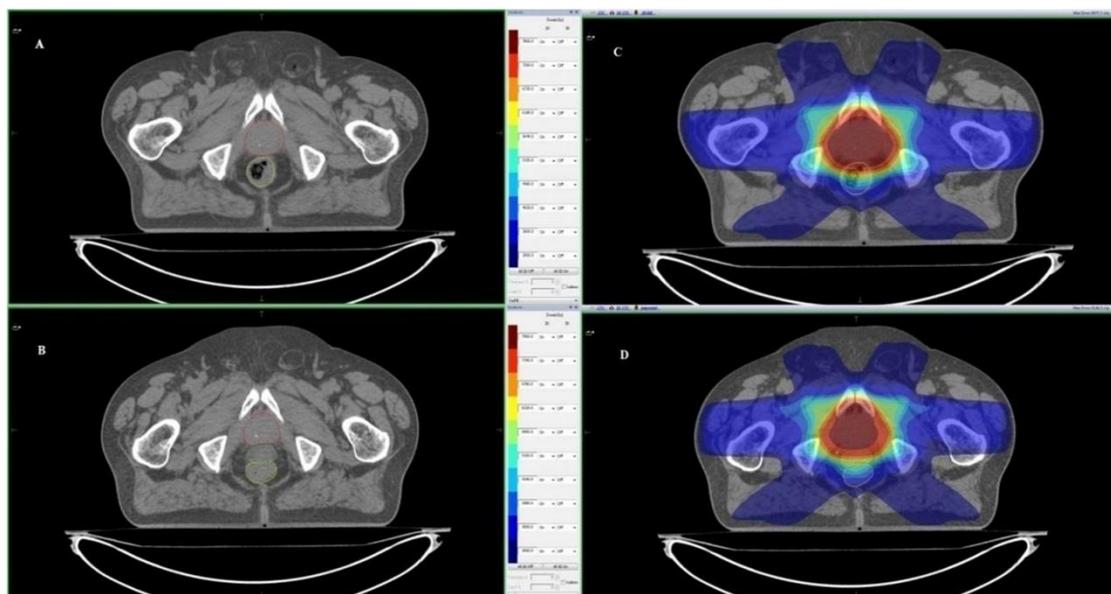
Axial plane abdominal CT images before (A) and after (B) hydrogel, and images of hydrogel planned by the conformal techniques before (C) and after (D) isodose distributions.
